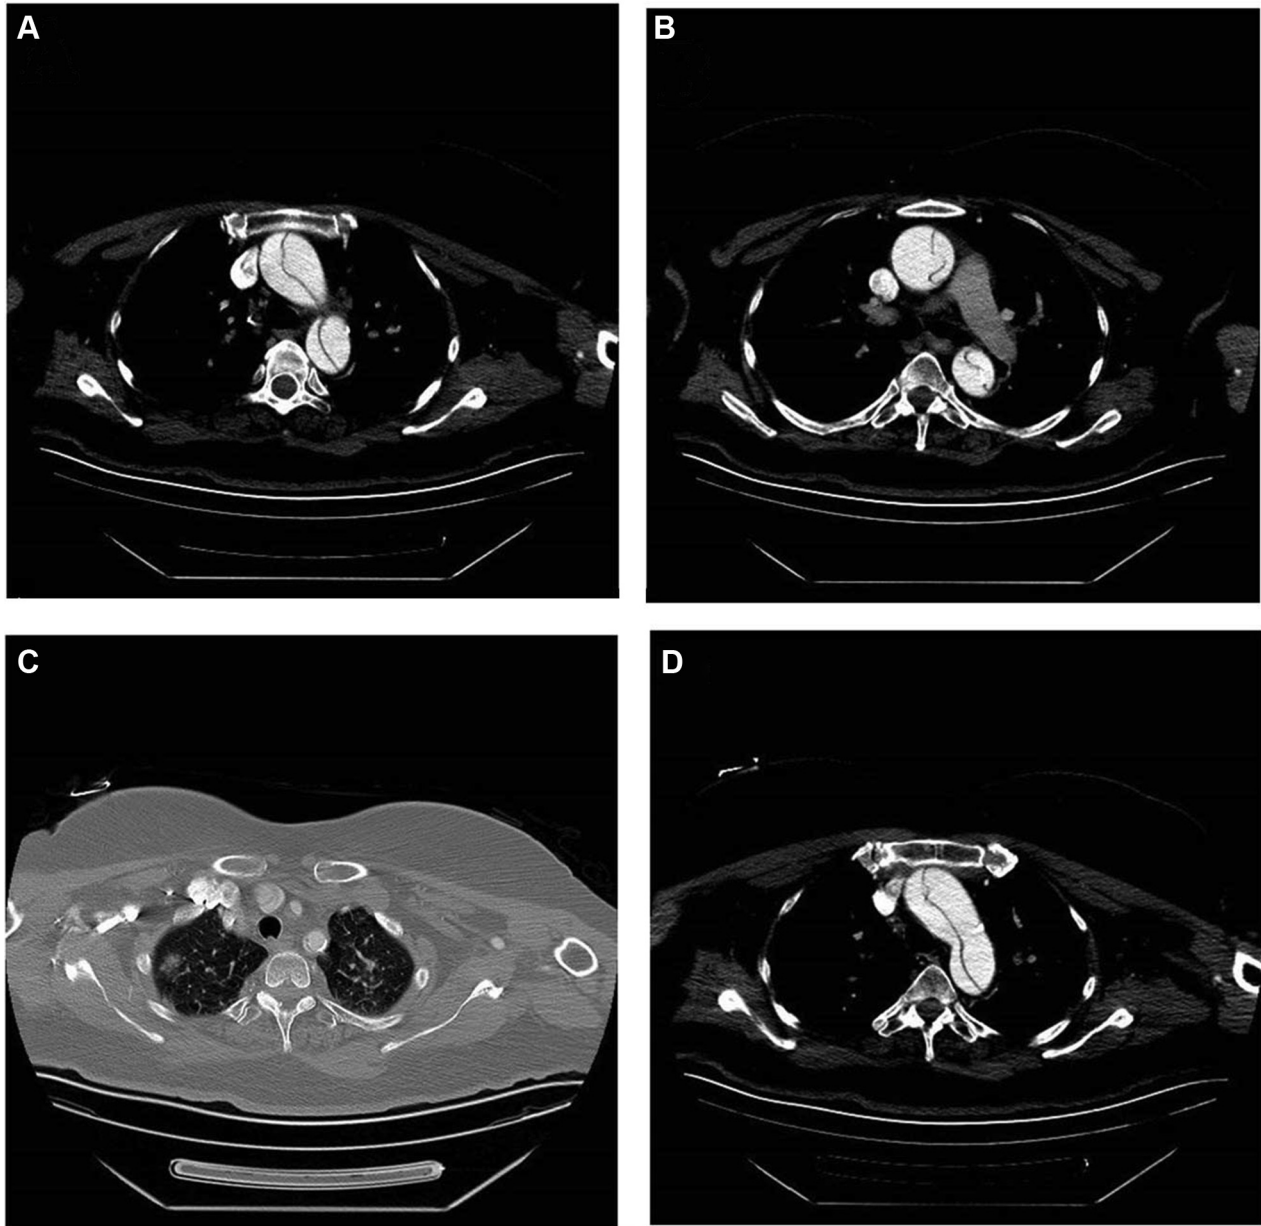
Computed tomographic images of the patient show (A, B, and D) the type A aortic dissection flap and (C) ground-glass opacities in both lungs, with nodular infiltration in the right apex.
